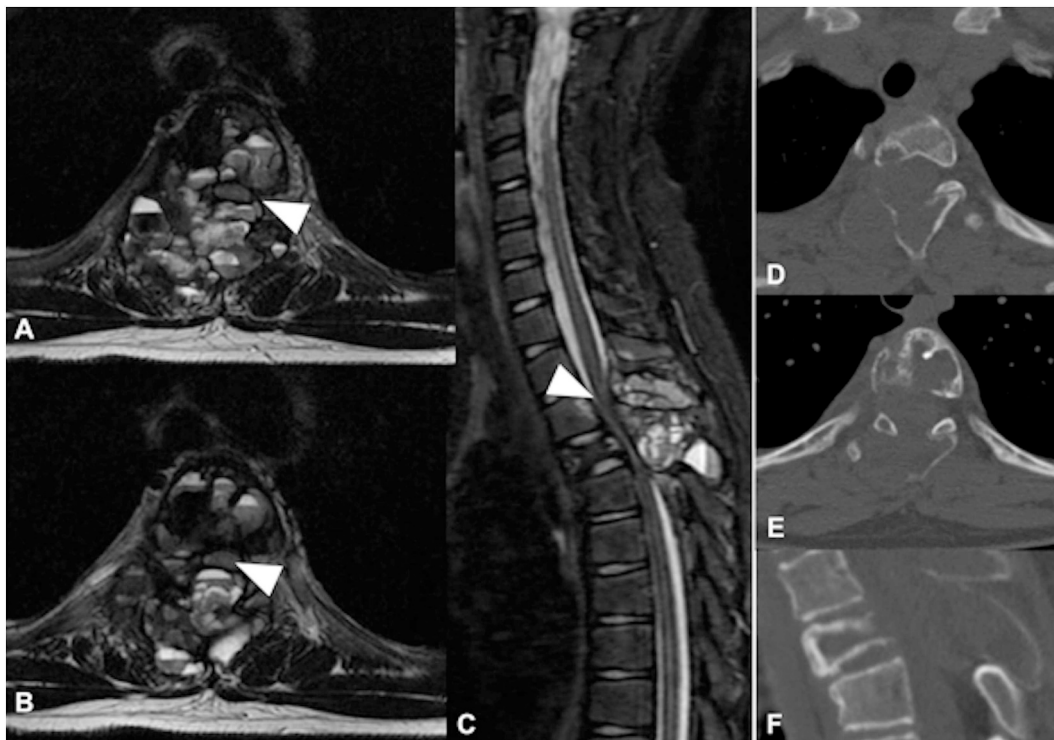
Axial T2 spin-echo with Fat-Sat MRI at level T3 (A) and T4 (B) showing the typical pattern of aneurysmal bone cyst with multi-loculated cysts (soap-bubble appearance) and fluid-fluid level (haemorrhagic component of the cysts) involving both vertebral bodies with extension to the right pedicles, laminae and spinous processes. There is epidural extension of the lesions leading to spinal cord compression at T3 and mainly T4 level (white arrowhead), as shown on axial and sagittal T2 SE Fat-Sat MRI (C). The CT-scan without contrast shows cortical erosion and balloon-like appearance of the cortical bone at level T3 (D) and T4; there was also a compression fracture of vertebra T4 with erosion of the posterior vertebral wall. (E & F).
